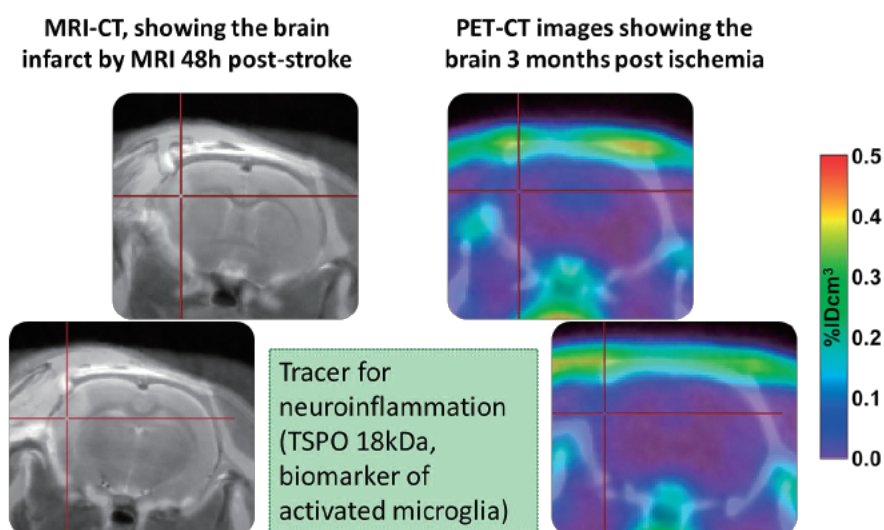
MRI CT images taken at 48 hours post stroke and PET-CT images taken at 3 months post ischaemia. No significant uptake of the tracer is seen.
